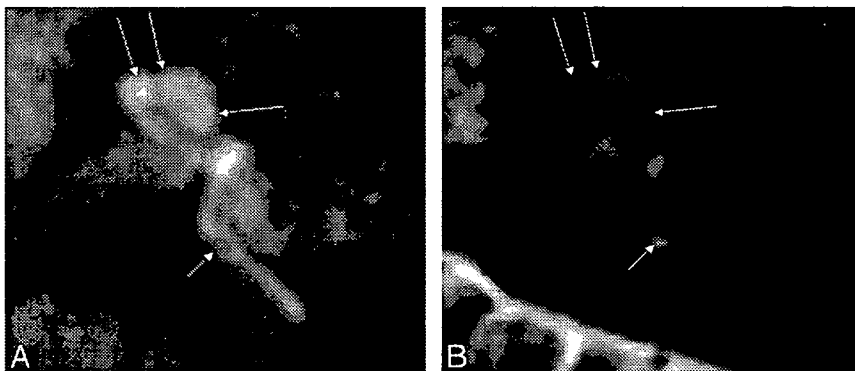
A 43-year-old woman with sudden sensorineural hearing loss in the left ear. All images were obtained 24 hours after the intratympanic injection of Gd-DTPA. *A*, Perilymphatic fluid image obtained with 3D-FLAIR (9000/128/2500). Areas of low signal intensity in the position of the cochlear duct (*arrows*) cannot be recognized as the endolymphatic space in the cochlea, probably because of their small size. Note that the endolymphatic space of the posterior ampulla (*short arrow*) showed low signal intensity. *B*, Endolymphatic fluid image obtained with a 3D inversion-recovery sequence (9000/128/1000). The endolymphatic space in the cochlea (*arrows*) cannot be recognized as high signal intensity on this image. Note that the endolymphatic space of the posterior ampulla (*short arrow*) showed high signal intensity alternatively compared with Fig 2*A*.
